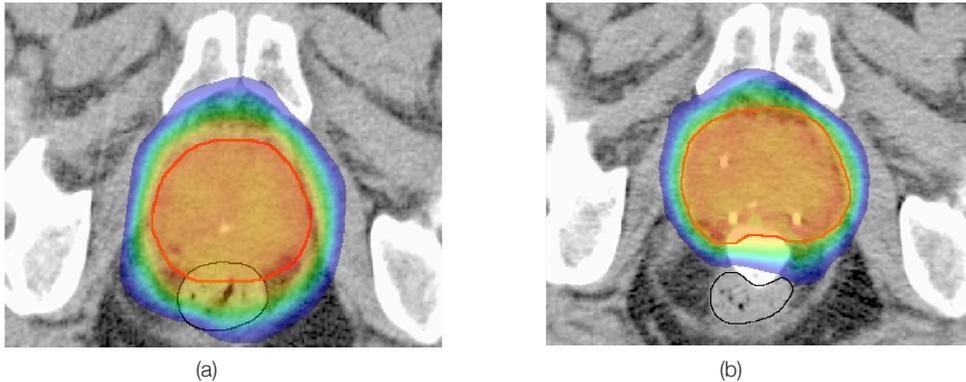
Color-wash isodose distribution projected on an axial CT slice before (a) and after RBI implantation (b) in the same patient with the planning target volume in red. Without RBI (a), the high-dose region >80% (green isodose) overlaps with the entire ventral part of the rectum (black line), whereas with the RBI in situ (b) the rectum is exposed to a dose <65% (blue isodose)
